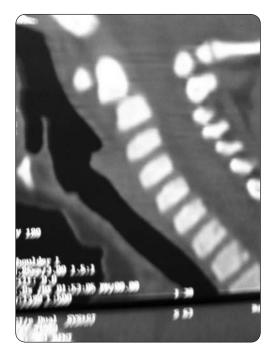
Preoperative sagittal MR and CT of the cervical spine showing the disrupted synchondrosis.
